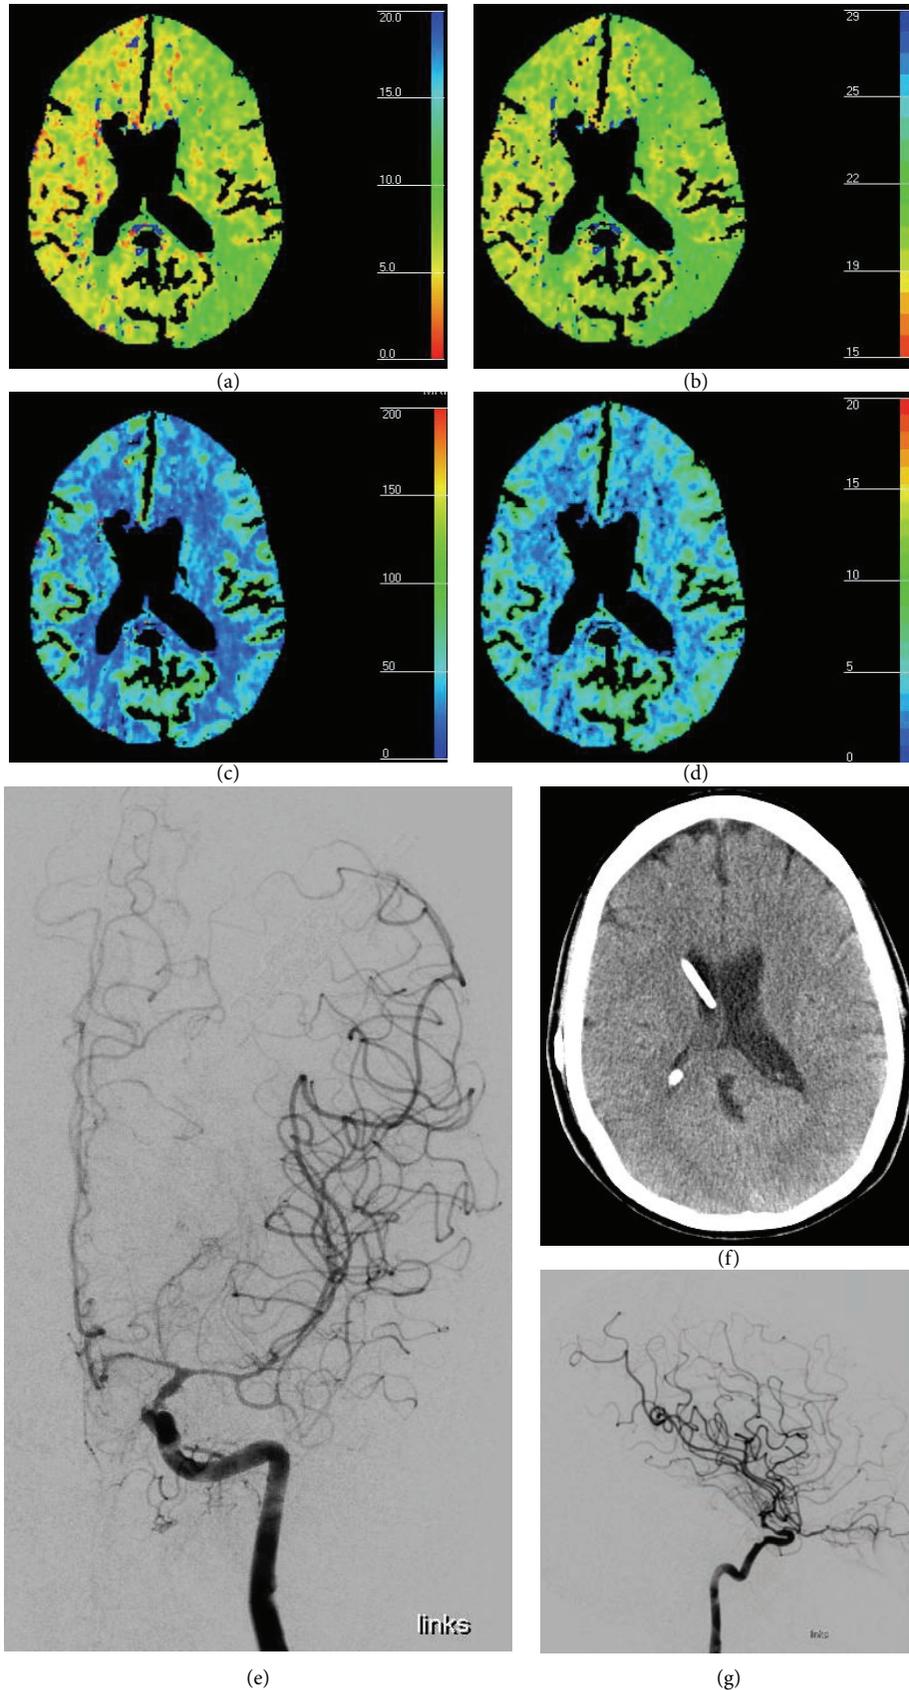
Perfusion CT correlating with DSA. CT perfusion with MTT (sec) (a), TTP (sec) (b), CBF (mL/100 g/min) (c), and CBV (mL/100 g) (d) showing circumscribed perfusion deficit on the territory of the left MCA. No evidence of infarction as shown on native CT scan (f). Digital subtraction angiography (e, g) of the left ICA from the same patient on the same day showing vasospasm of the left ICA above the ophthalmic artery of the median and anterior cerebral artery.
